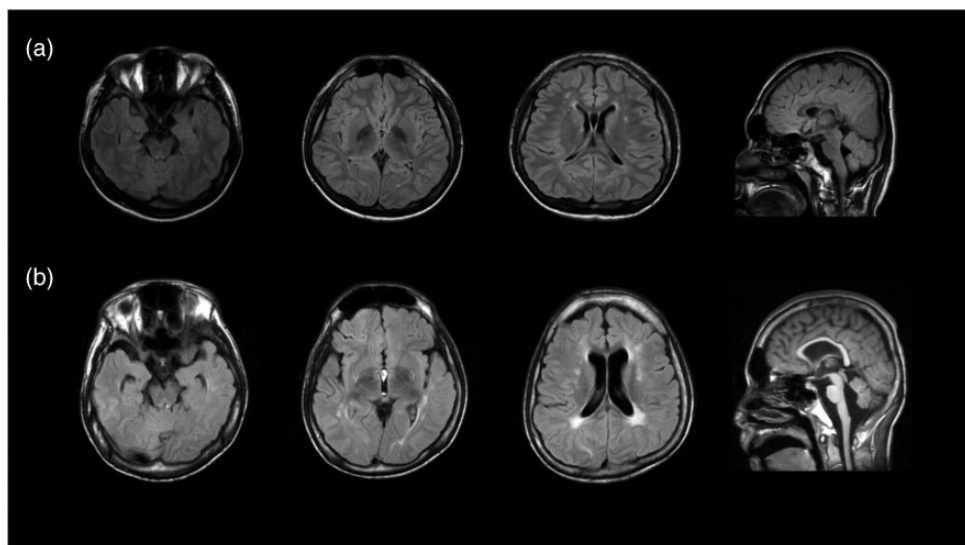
Brain MRI findings of the siblings. (a) MRI of the patient showing a focal volume decrease in the splenium of the corpus callosum as well as several non-specific T2 hyperintense lesions in the white matter and (b) MRI of the patient's brother showing multiple T2 hyperintensities in the periventricular and deep white matter.
